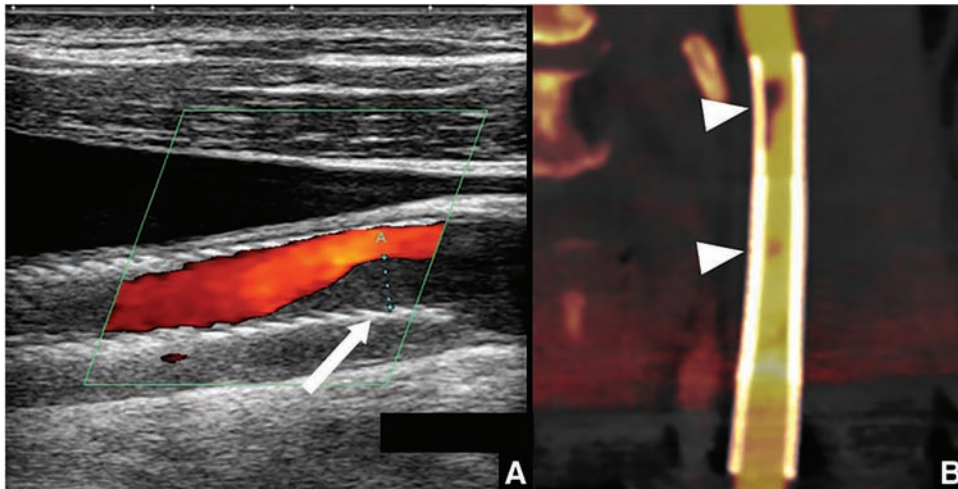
(A) Ultrasonography reveals low-echoic deposits distal to the stent (white arrow), suggesting plaque protrusion. Mobile thrombus is attached to the protruding plaque. (B) CTA shows plaque protrusion at the distal end of the Carotid Wallstent and sites of areas of stent overlap (white arrowheads).
